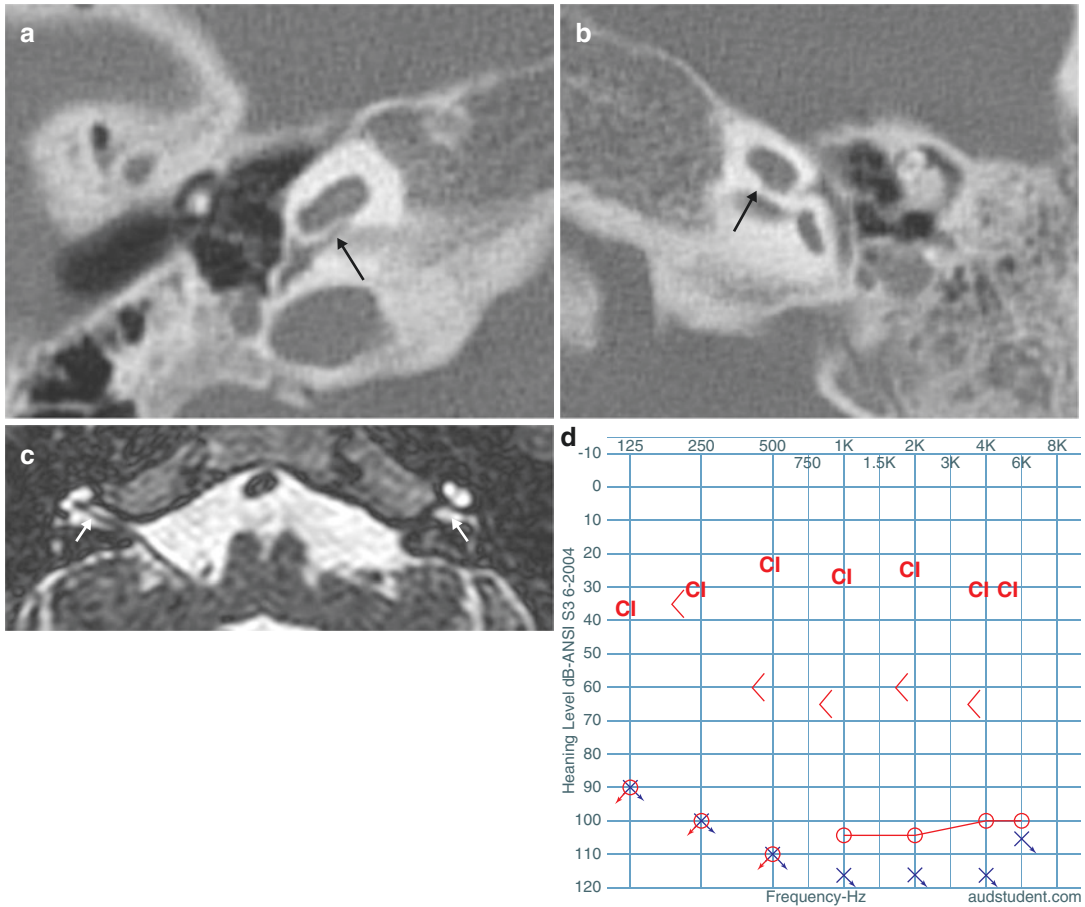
Case 2. Temporal bone CT axial mid-modiolar section showing bilateral cochlear hypoplasia type III, bilateral CA stenosis (a and b), MRI section showing aplastic CN
